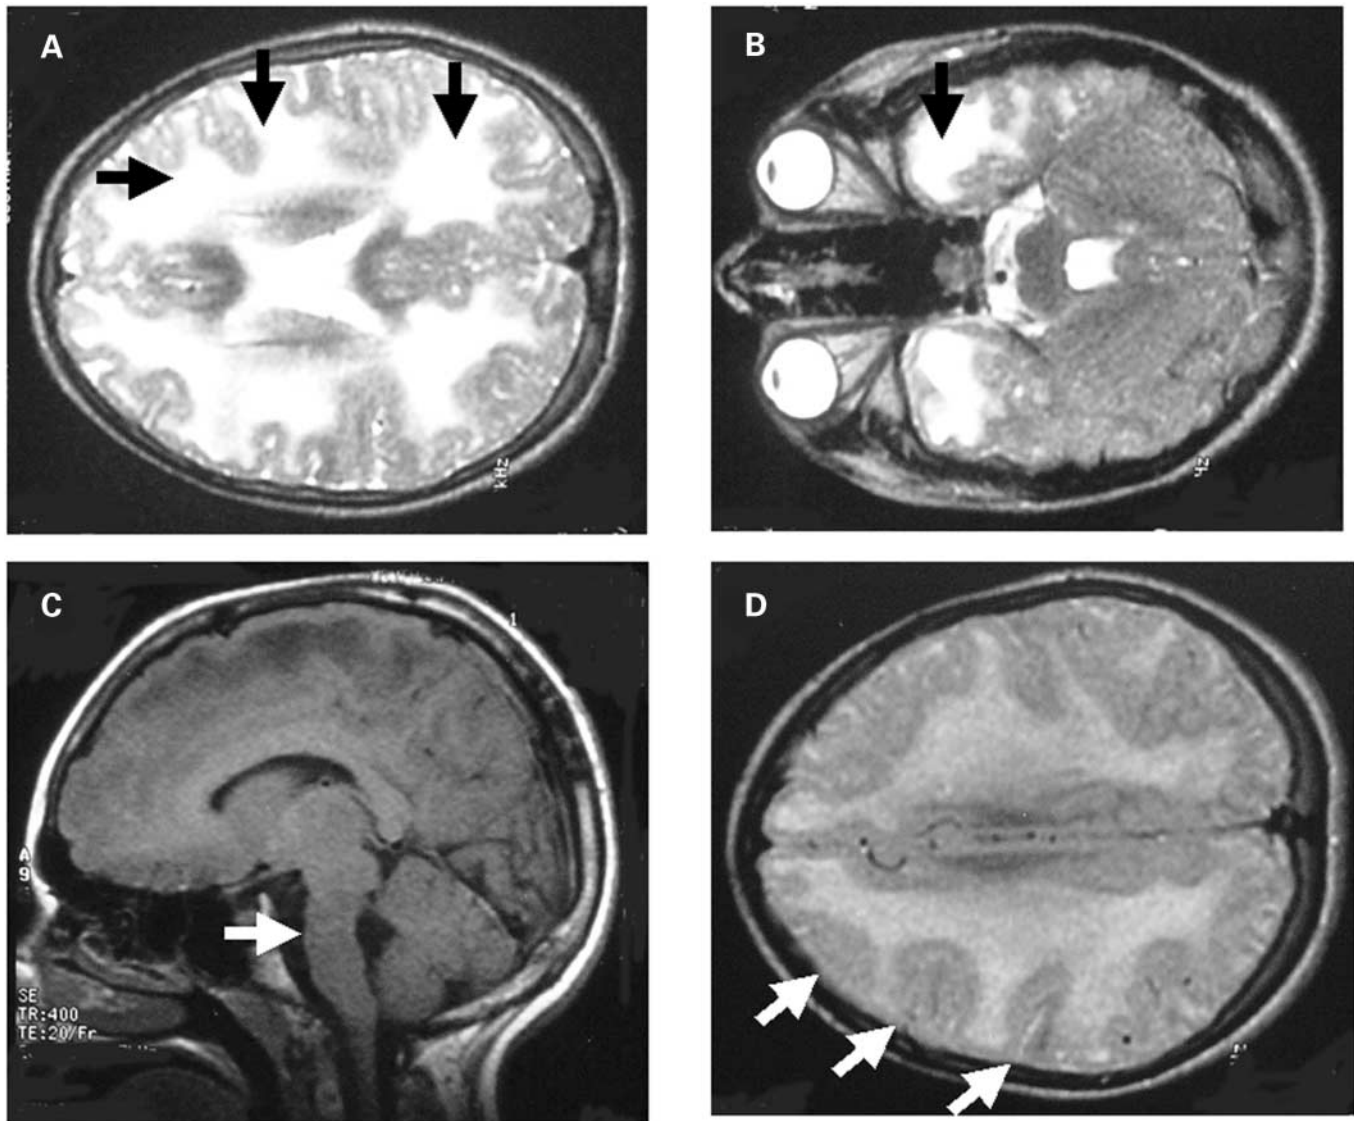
Magnetic resonance imaging of brain, age 14 years. (A) T_2 -weighted image, transverse plane. There is bilateral, symmetrical, increased signal intensity in white matter (arrows). (B) T_2 -weighted image, transverse plane. Increased signal intensity of white matter preferentially affects temporal regions (arrow). (C) T_1 -weighted image, sagittal plane. There is a mildly hypoplastic brainstem. The pons is slightly flattened (arrow). (D) T_1 -weighted image, transverse plane. There is mild pachygyria with moderately thickened cortex in the frontal lobes, and mildly simplified gyri with shallow sulci in the posterior frontal, temporal and parietal regions (arrows).
